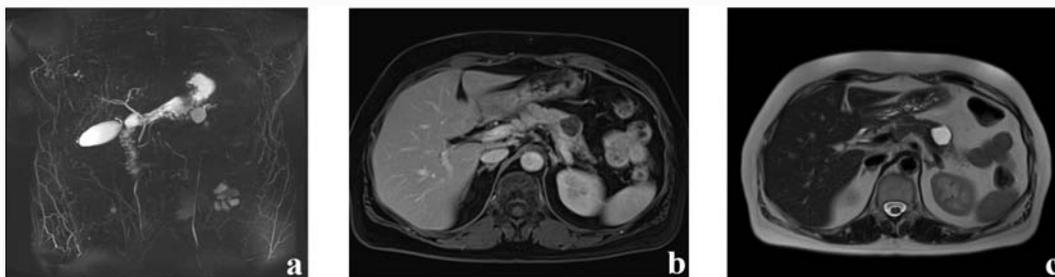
Magnetic resonance imaging with multiplanar in/out T1, T2 and T2fs, DWI, 3D cholangiopancreatography, T1fs sequences pre- and post-intravenous contrast injection with dynamic study and pancreatic protocol, showing a nodular lesion of the pancreatic tail, with maximum diameter of 23 mm.
